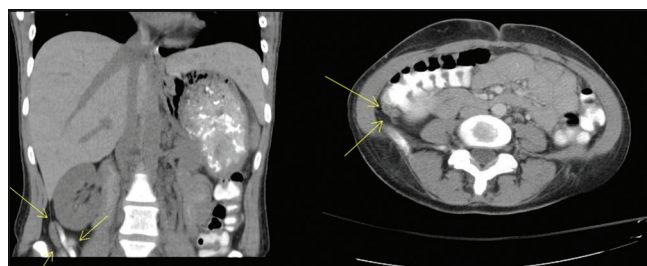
Computed tomography scan showing an acute appendicitis
